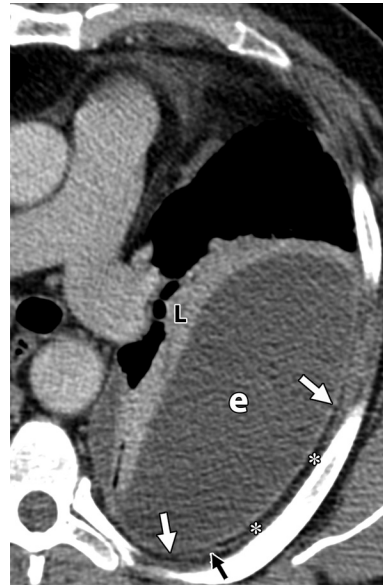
Fibrinopurulent phase of empyema and increased extrapleural adipose tissue. Axial targeted reconstruction CT image of the left hemithorax shows a loculated left pleural effusion (e) exerting a mass effect on the adjacent lung (L), diffusely thickened and enhancing parietal pleura (white arrows), and an increase in extrapleural adipose tissue (*). Also note the intercostal vein (black arrow).
